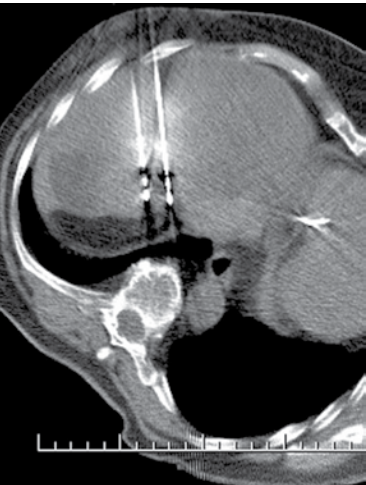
(b) CT scan shows microwave antennae in the center of the lesion.
